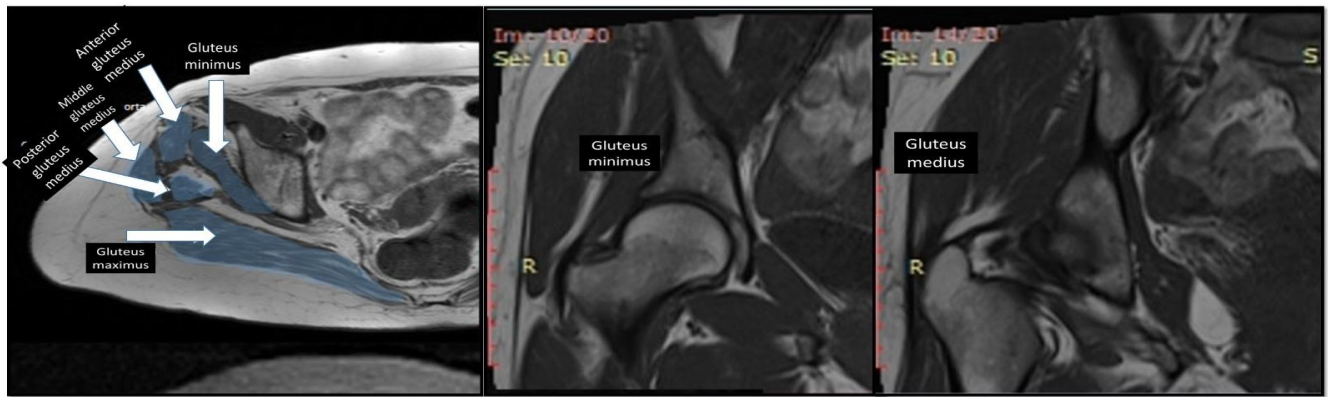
MRI demonstrates asymmetric fatty atrophy of the gluteal musculature, particularly involving the gluteus medius/minimus complex
